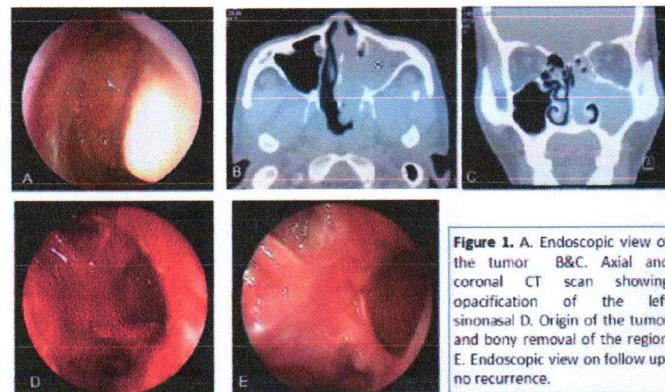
A. Endoscopic view of the tumor B & C. Axial and coronal CT scan showing opacification of the left sinonasal D. Origin of the tumor and bony removal of the region E. Endoscopic view on follow up: no recurrence.
